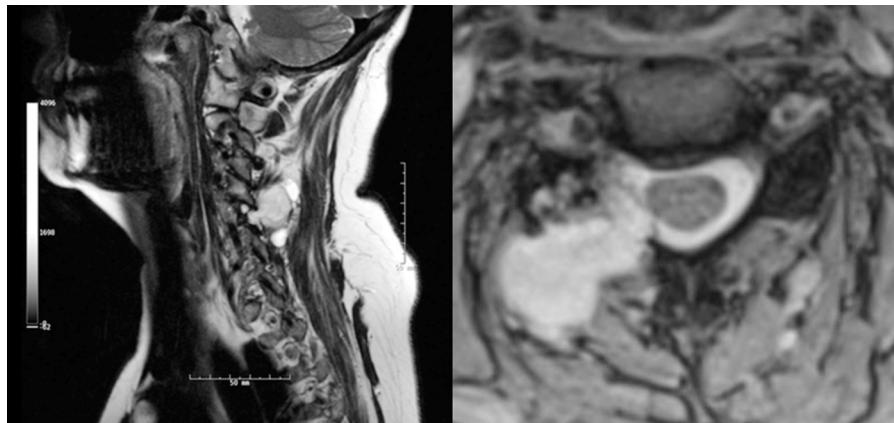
Magnetic resonance imaging (sagittal and axial views) revealing a 27×16×38 mm enhancing lesion at C4–C5, involving the right paraspinal soft tissues with extension into the spinal canal.
